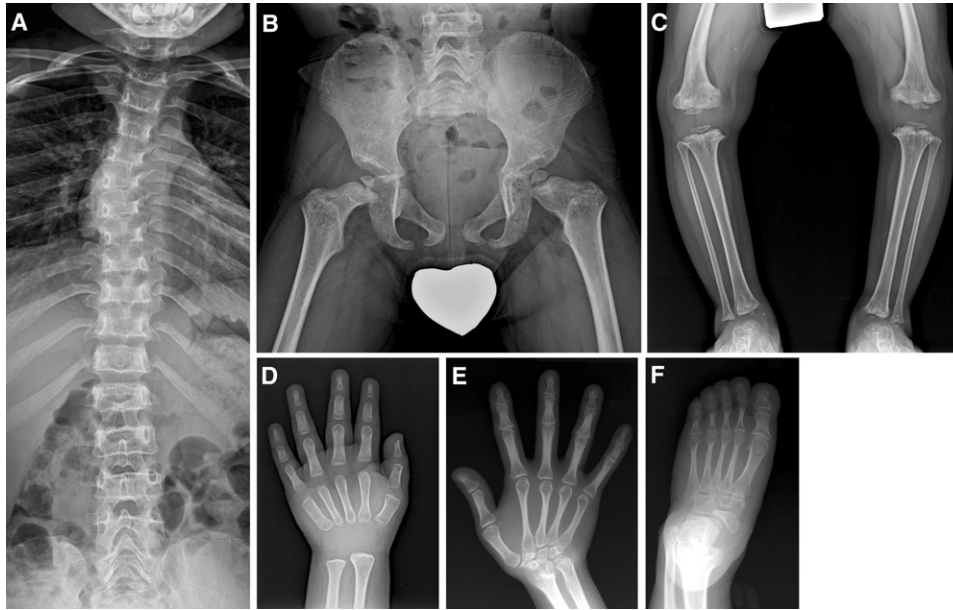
Radiographic Characteristics of Lepto-SEMDJL
